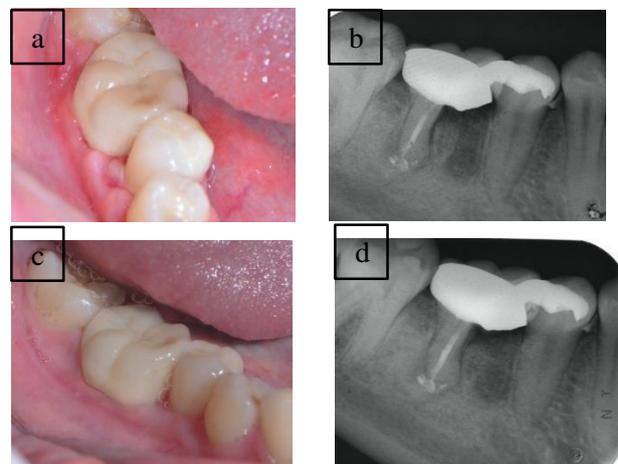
Clinical view of tooth 46 and 45 crowns after cementation (a) occlusal and buccal, (b) radiographic view of post crown cementation, (c) clinical view of occlusal and buccal after 1 week, (d) Radiographic view of tooth 46 and 45 crowns after 1 week
